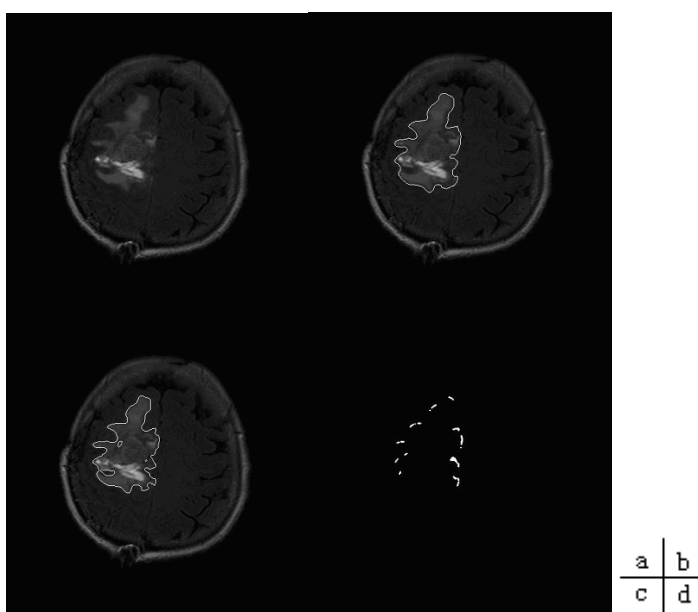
Examples of Patient 2 with and without feature selection (FLAIR images)
